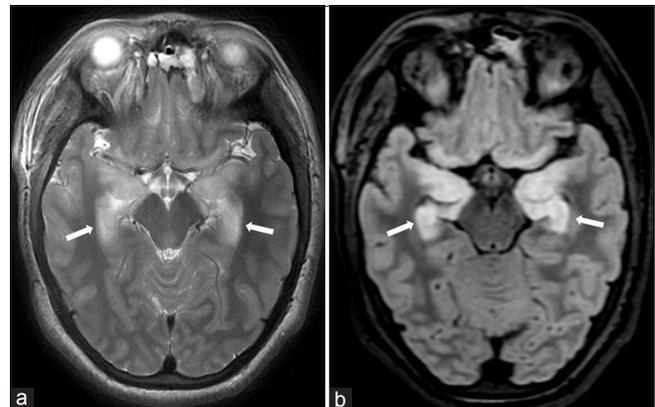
Axial T2-weighted image (a) and fluid attenuated inversion recovery (b) of brain shows hyperintensity in bilateral hippocampus.
